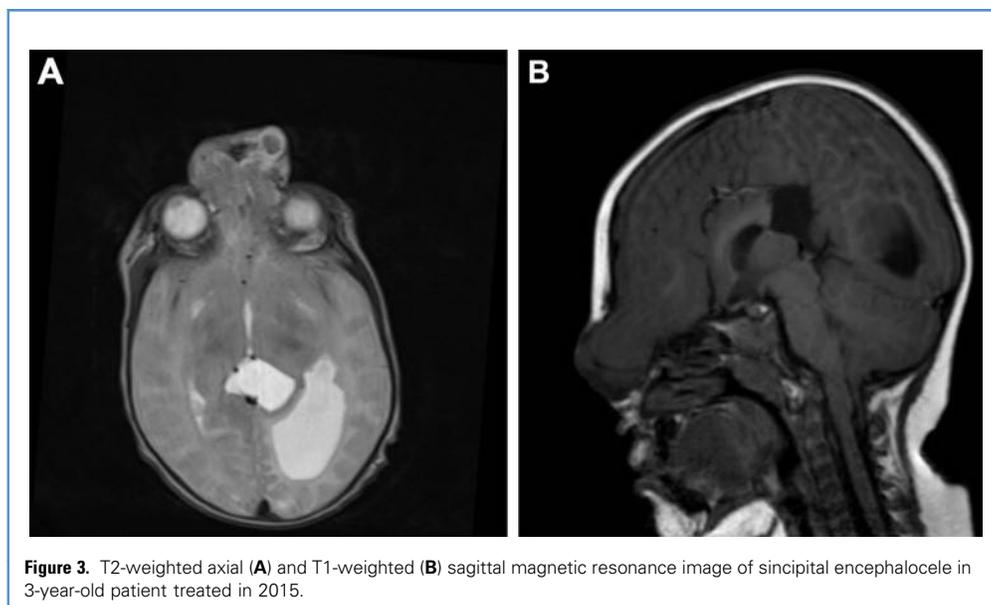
T2-weighted axial (A) and T1-weighted (B) sagittal magnetic resonance image of sincipital encephalocele in 3-year-old patient treated in 2015.
